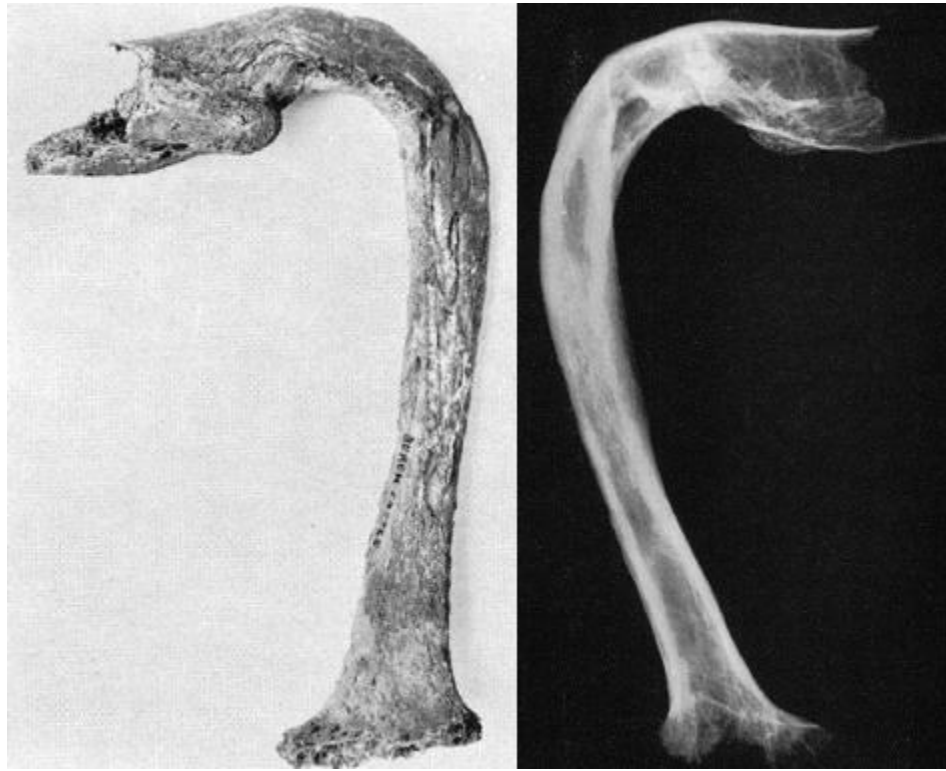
Paleopathological adult femur diagnosed with osteogenesis imperfecta. Severe bending is noted at the proximal end. Radiographs show reduced trabeculae that is also irregular and coarse, flaring at the distal metaphyses, and a narrow shaft (after Wells 1965:89-90).
